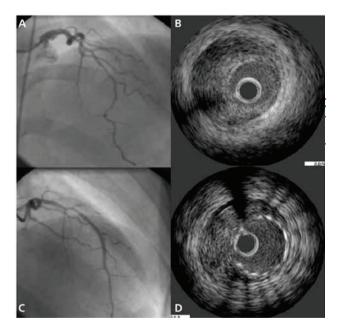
Coronary angiography of the left coronary tree (A) in AP cranial projection; image of aneurysm in the left coronary tree and diffuse and long narrowing of all the anterior descending coronary artery. Normal circumflex artery. Intracoronary ultrasound (B) targeting image of dissection and associated hematoma in left coronary tree. Circumferential medial adventitial dissection in the anterior descending artery, with large intramural hematoma from ostium to distal segment, but without intimal flap. After stent implantation in proximal and medial ADA due to flow involvement, coronary angiography (C) shows good caliber and flow in that vessel. Intracoronary ultrasound (D) showing correctly placed stent with residual hematoma between the stent and the adventitia.
